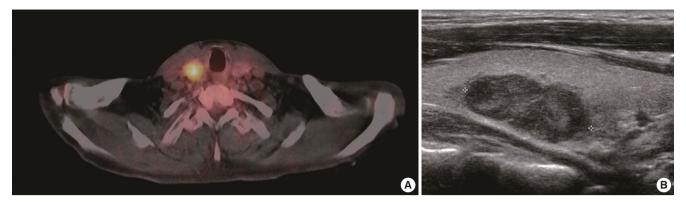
PET scan and Ultrasound finding. (A) PET scan shows focal hypermetabolism in the right lobe of thyroid gland (SUV 2.5). (B) Ultrasonography shows marked hypoechoic solid nodule with lobulated margin with inner microcalcification, measured 1.6 × 1.0 × 2.5 cm (2.42 cm³), in right mid pole.
